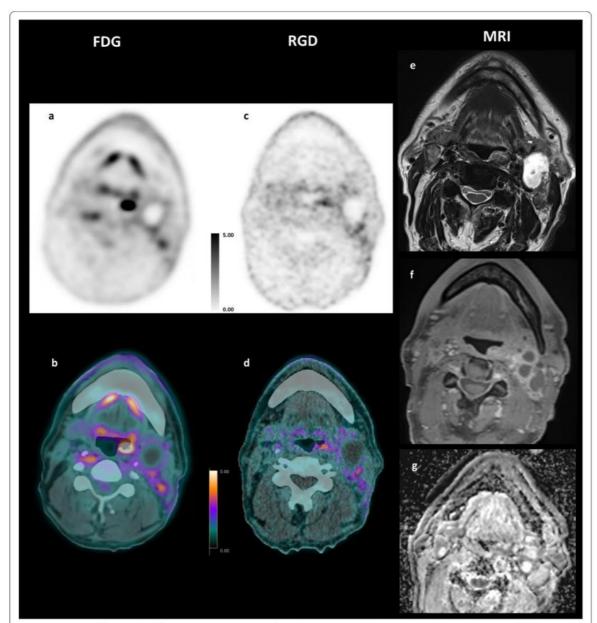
Comparative ¹⁸F-FDG (a, b), ⁶⁸Ga-NODAGA-RGD PET/CT (c, d), and MRI (e T2w axial, f T1w post Gadolinium, g ADC map of diffusion), of patient #9 (59-year man with moderate differentiated left tonsil squamous cell carcinoma). The ¹⁸F-FDG and ⁶⁸Ga-NODAGA-RGD PET images showed different signal-to-noise ratios and a slightly different distribution of activity within the tumor bed. The left cervical lymph node showed a photopenic center with absence of tracer uptake for both tracers corresponding to necrosis on MRI
